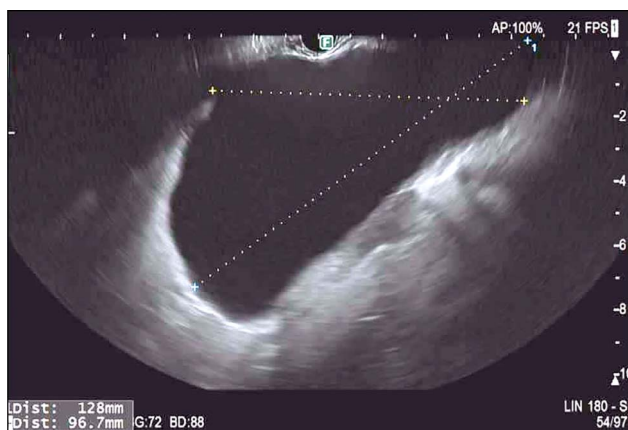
EUS image of 128×97 mm cyst located in the pancreatic body. EUS, endoscopic ultrasound.
